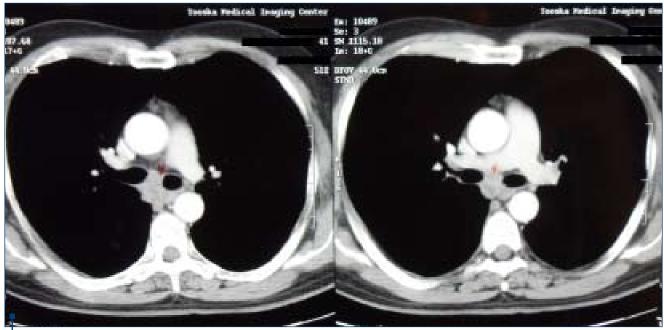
Close view of the involved airways in CT
